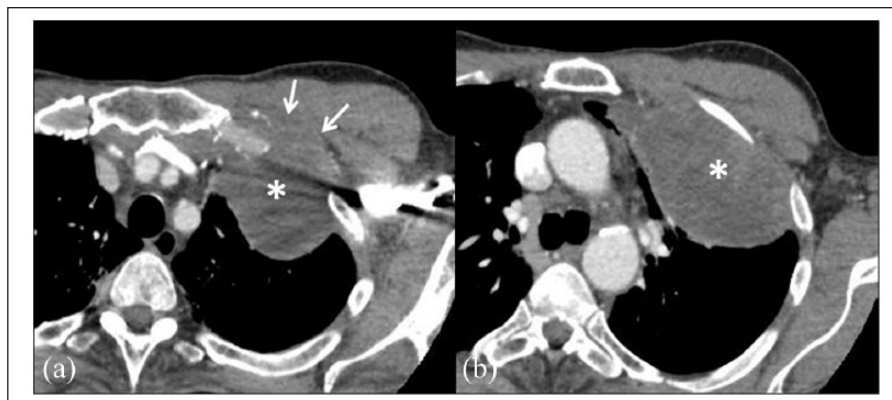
CT chest with contrast, pre-chemotherapy. (a) Superior aortic arch. (b) Carina. CT chest with contrast at the level of the superior aortic arch (a) and carina (b) prior to treatment demonstrates a large soft tissue mass (asterisk) within the left anterior hemithorax. There is invasion of the mass into the left upper lobe and the superior chest wall (arrows).
